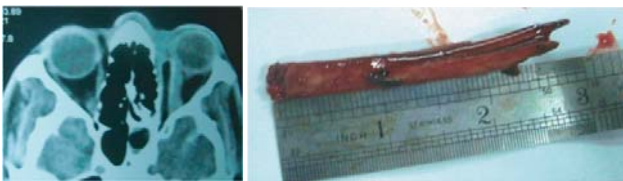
A 29-year-old-male patient presented with Optic Nerve avulsion of the left eye due to periorbital trauma accidentally by a long bamboo stick. Axial CT image of the orbit shows a long hypo dense lesion with surrounding heterogeneous hyper densities due to tissue oedema and inflammatory changes suggestive of the wooden foreign body in the left orbit.
